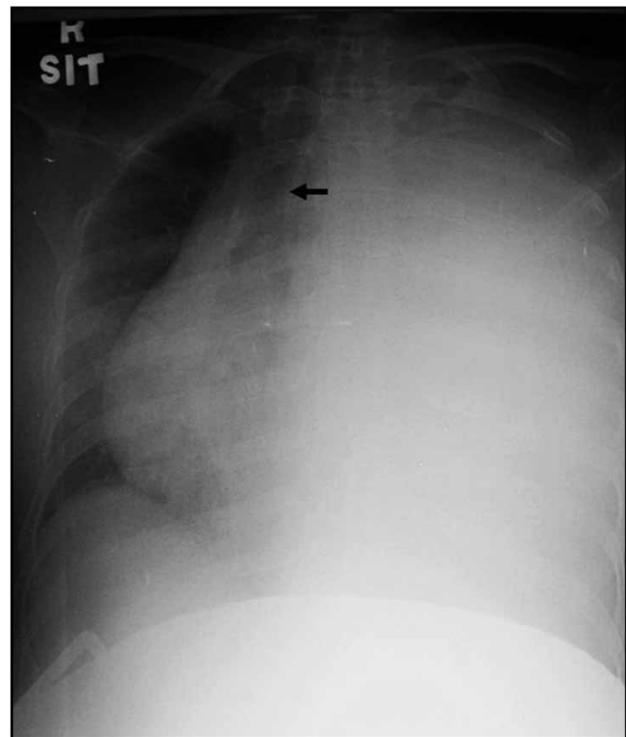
A chest X-ray of a patient at 32-week gestation (note the pelvic shield) presenting with dyspnoea and hypotension. The entire left hemithorax is opacified. There is mediastinal shift and tracheal deviation (arrow)
